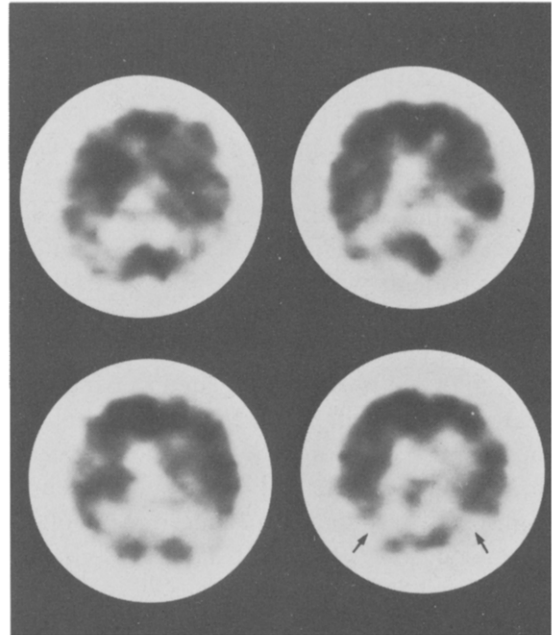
Case 3; CT shows some cortical tissue loss (a), while SPECT reveals bilateral areas of reduced uptake in the parietooccipital regions suggesting Alzheimer's disease (b).
